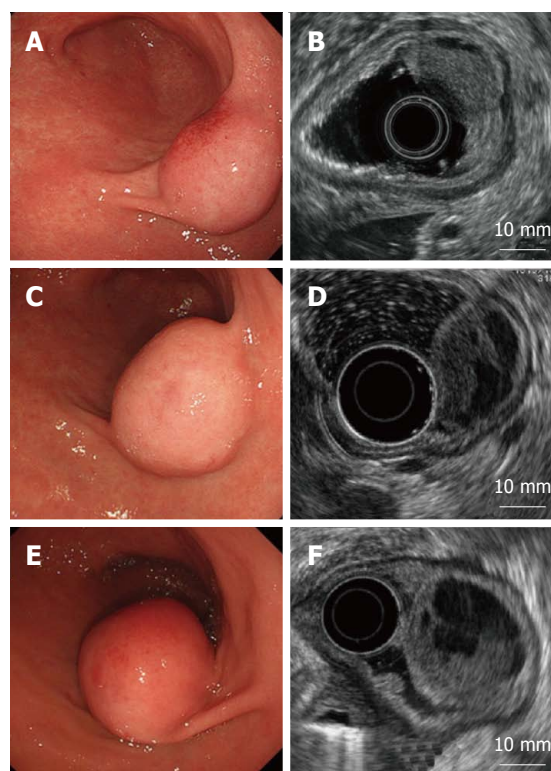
Endoscopic and endoscopic ultrasound findings. A: A submucosal tumor covered with a normal mucosa; B: An iso/hypoechoic mass with cystic components in the third layer; C, D: One year later; E, F: Four years later. The tumor increased in size and became pedunculated. Solid and multicystic parts both grew larger without muscle invasion.
